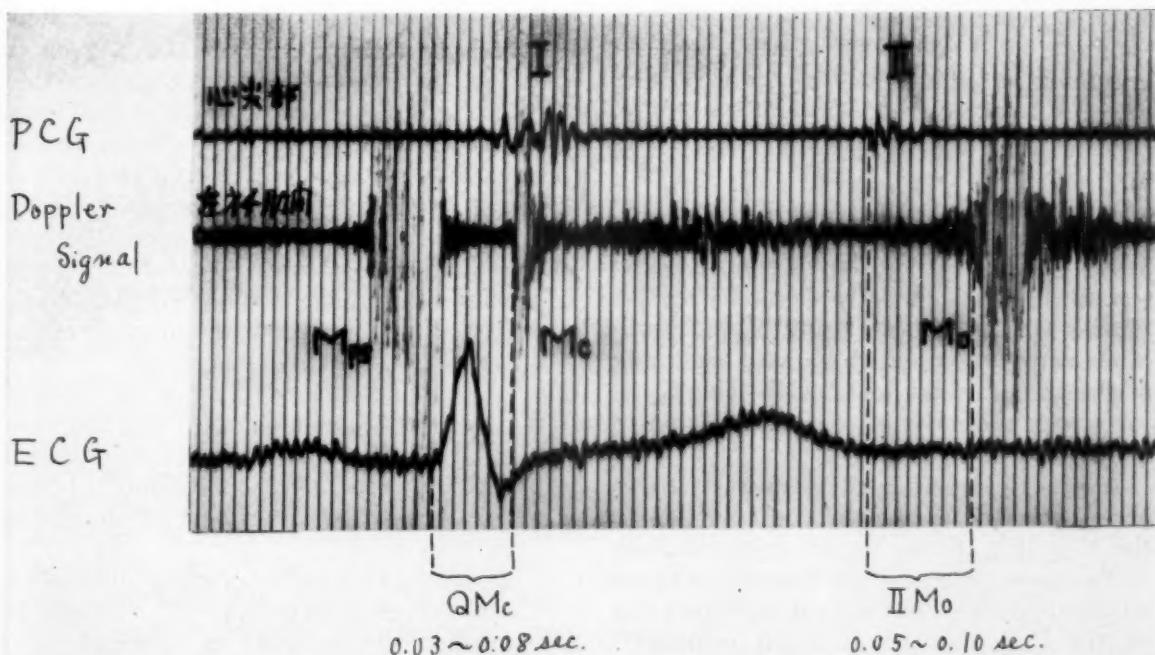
Ultrasonic Doppler signal of high frequency interpreted to be related to the mitral valve. *Mc*: Closing. *Mo*: Opening. (S. N., a 35-year-old man.)
